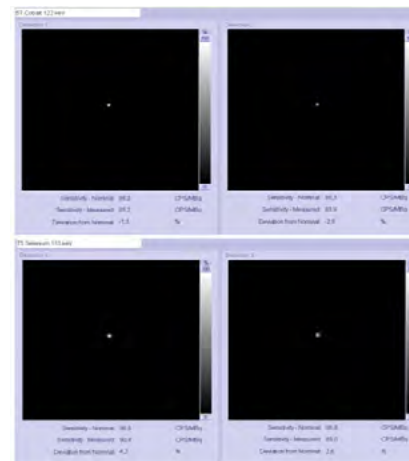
Monthly test; sensitivity of ^{57}Co and ^{75}Se point sources, which are used for absolute quantification in SPECT/CT.
